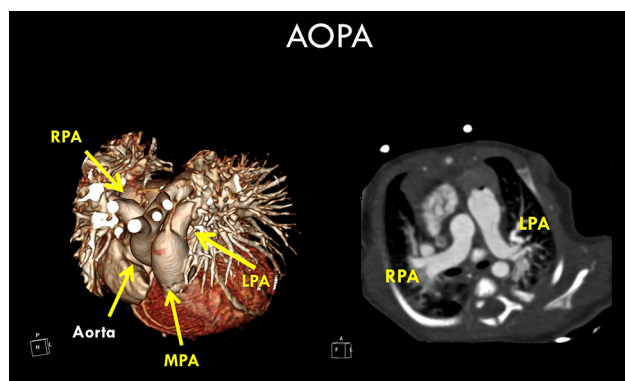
Preoperative computed tomography image of abnormal origin of the right pulmonary artery from the ascending aorta. RPA right pulmonary artery, LPA left pulmonary artery, MPA main pulmonary artery
